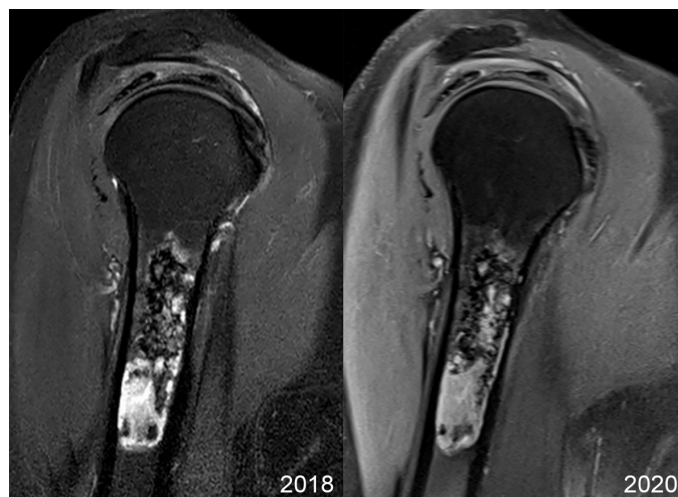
Female, 60 years: Enchondroma. MRI for rotator cuff evaluation. Proton-density-fat-saturated images show the enchondroma with a length of 63 mm unchanged over 2.8 years.
